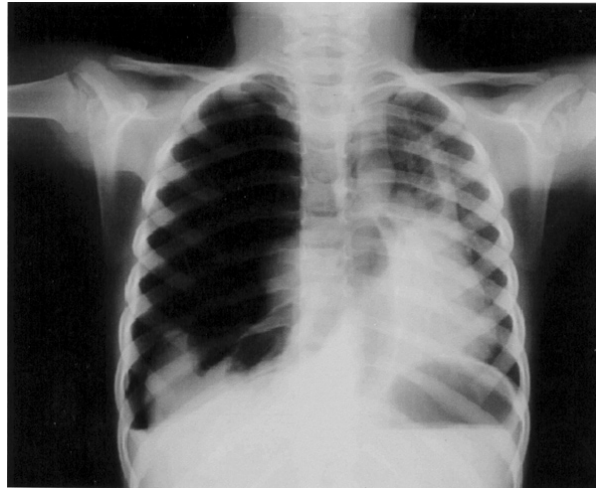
Plain chest X-ray showing right side tension pneumothorax, with shift of the mediastinum to the left side. Small right side plural effusion is noted.
